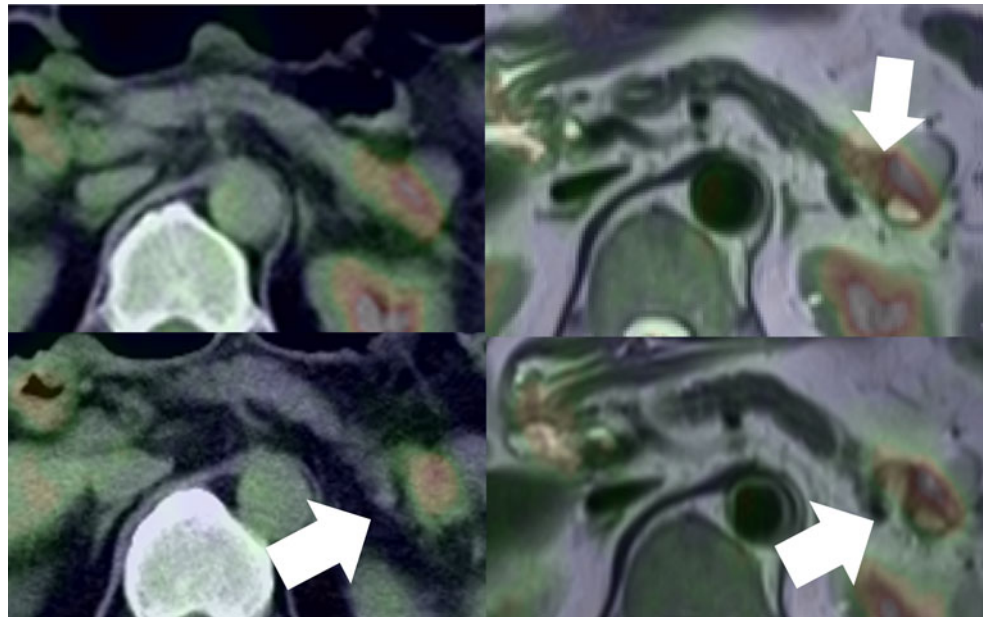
Low-dose CT showed localized swelling of pancreatic body (*left upper*). Intense FDG uptake was noted in pancreatic body by PET/CT (*left lower*) and the case was considered as pancreas cancer. PET/MRI-T1WI fusion image showed similar information (*right*
